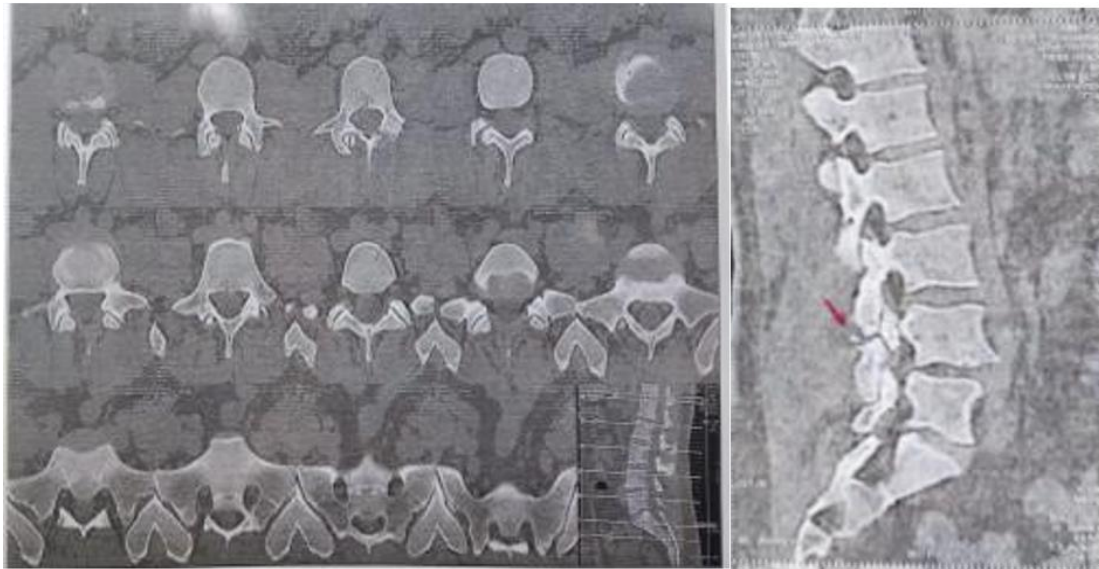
Preoperative CT lumbosacral spine Axial & Sagittal view of male patient 51 years old, with L4-L5 first degree isthmic spondylolisthesis
